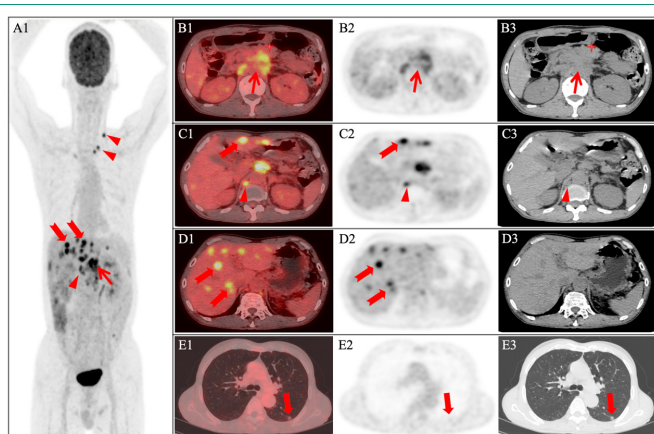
^{18}F -FDG PET/CT images of the patient with exophytic PDAC and multiple metastases to lymph nodes, liver and lung. (A1) The maximum intensity projection (MIP) image of ^{18}F -FDG PET/CT shows multiple and intense ^{18}F -FDG-avid lesions in the mid-abdomen, liver, and left supraclavicular area. (B1-B3) Axial fused PET/CT, PET, and CT images indicate a soft tissue mass (thin red arrows) in the posterior of the pancreatic body with SUV_{max} of 7.7. A red asterisk represents a normal pancreatic body. (C1-C3) Axial fused PET/CT, PET, and CT images detect metastatic lymph nodes (red triangles) in the abdominal cavity and retroperitoneal with SUV_{max} of 5.9. (C1-C2 and D1-D3) Axial fused PET/CT, PET, and CT images display multiple liver metastases (red dovetail arrows) with SUV_{max} of 9.5. (E1-E3) Axial fused PET/CT, PET, and CT images show lung metastases (thick red arrows) with SUV_{max} of 1.5.
